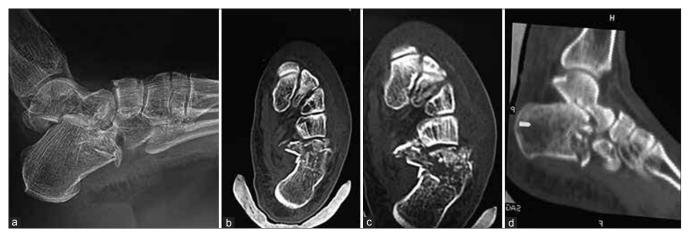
Preoperative X-ray ankle joint (a) and noncontrast computed tomography of the first case (b,c,d) showing comminuted fracture of the anterior end of the calcaneum with posterior facet dislocation of the talus
